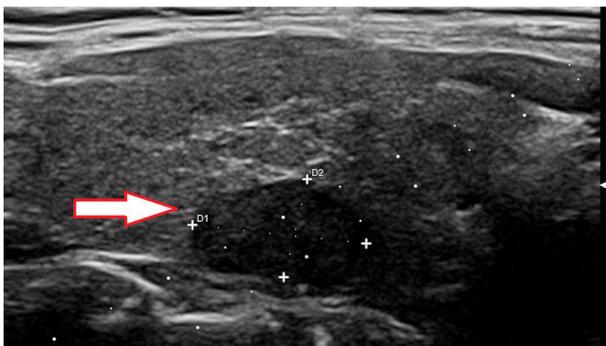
Ultrasound features of medullary thyroid carcinoma (arrow) before radiofrequency ablation
